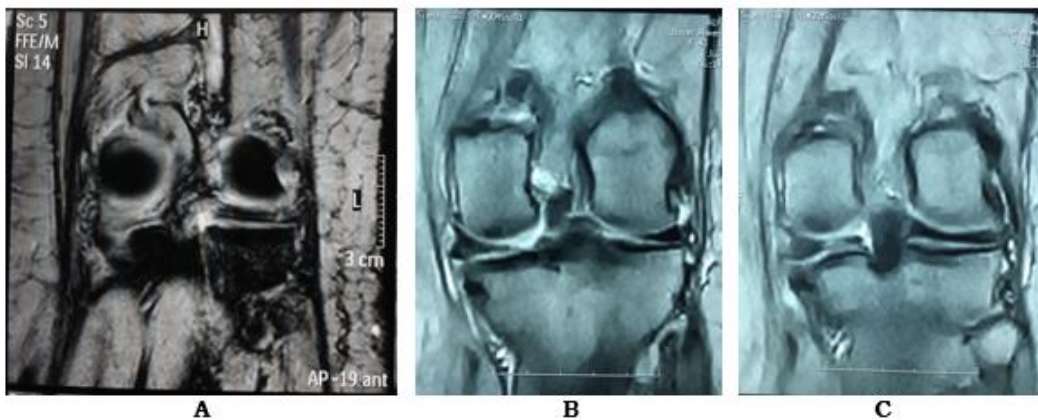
42 years old female patient presented with left knee pain, tender joint line, and MRI was done revealed PRTMM. Preoperative Lysholm score was poor and IKDC was 39.1, while postoperative Lysholm score improved to good and postoperative IKDC improved to 70.1 (a) Photograph of MRI showing PRTMM lesion, (b&c) Photograph of 6 months postoperative MRI showed healed meniscus root in a good reduction and anatomical position
